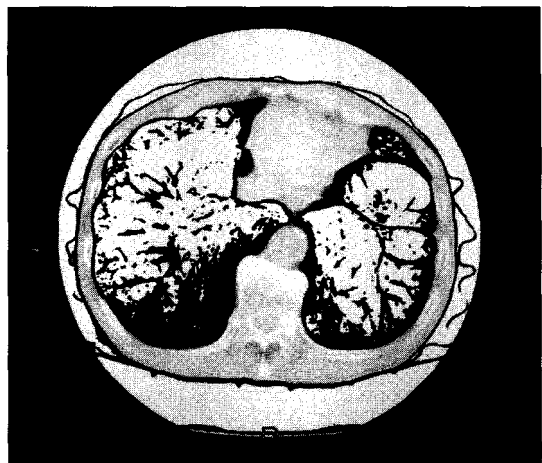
Low attenuation area of the lung <-950 HU on high resolution computed tomography in patient with pulmonary emphysema.
